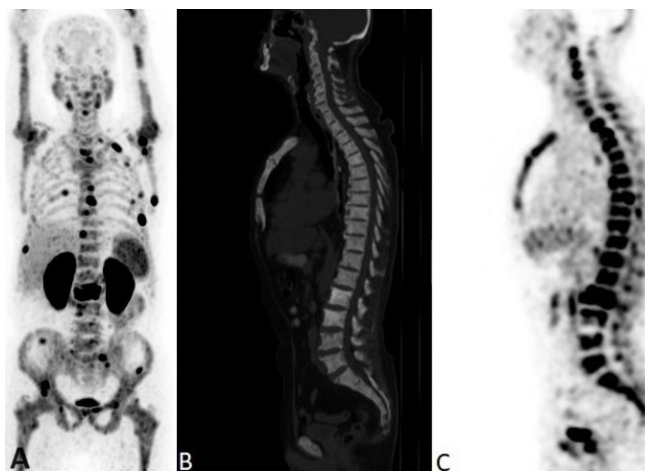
^{68}Ga -PSMA PET/CT with maximum-intensity projection (A), sagittal CT (B), and sagittal PET (C) images of a 75-year-old patient with PCa (GS 5+5) with a PSA level of 64.0 ng/mL. ^{68}Ga -PSMA PET/CT images showed multiple sclerotic bone metastases
